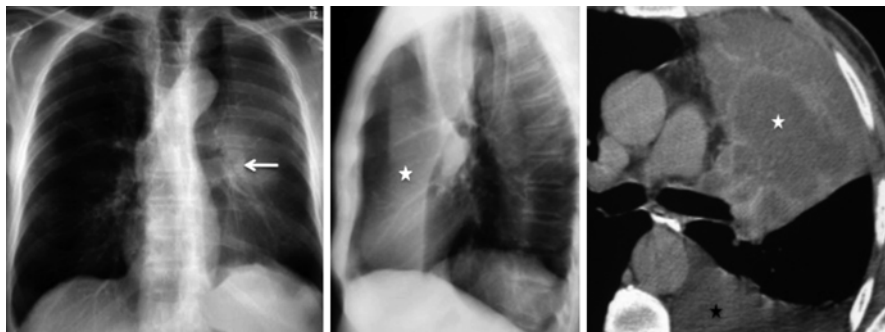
A 57-year-old male smoker with haemoptysis. Frontal CXR (*Far left*): There is a veil like opacity in the left upper lobe (*arrow*) with volume loss as evidenced by hilar retraction, rib crowding and mediastinal shift. The collapsed lobe (*white star*) is demarcated by the major fissure on the lateral film (*mid panel*). Axial CT image (*far right*) demonstrates a necrotic mass extending from the left hilum (*white star*). Also note the left pleural effusion (*black star*)
